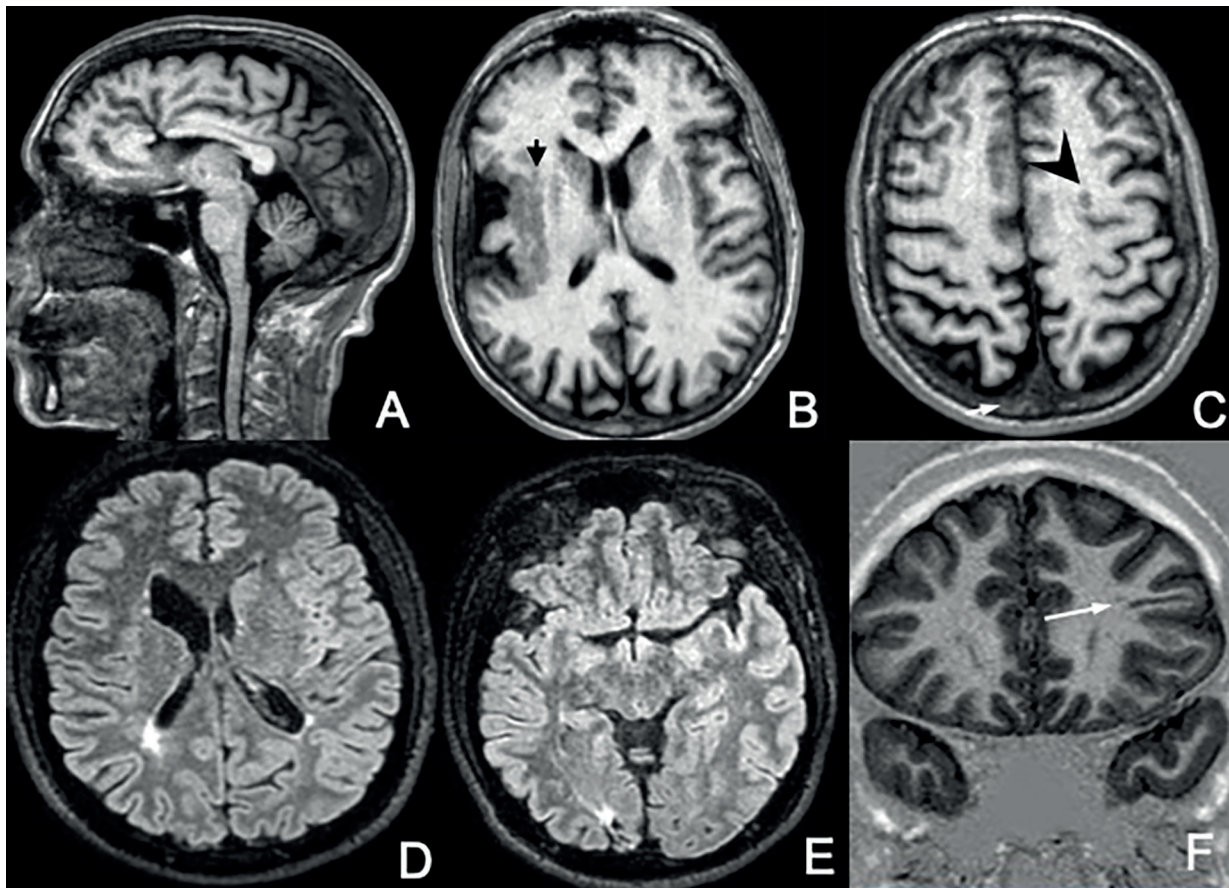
Magnetic resonance imaging findings of the two patients. Letters A-C correspond to patient 1 and letters D-F correspond to patient 2. A, Sagittal T1-weighted image showing left frontal closed-lip schizencephaly. B, Axial T1-weighted image showing polymicrogyria adjacent to schizencephaly and areas of nodular heterotopia in the right white matter (*black arrow*). C, Axial T1-weighted image showing nodular heterotopia in left subcortical white matter (*arrowhead*). D, Axial FLAIR image showing porencephaly with enlargement of right lateral ventricle as well as leukoaraiosis. E, Axial FLAIR image showing right occipital cortico-subcortical encephalomalacia. F, Coronal inversion recovery image showing a thin band of heterotopia (*white arrow*).
